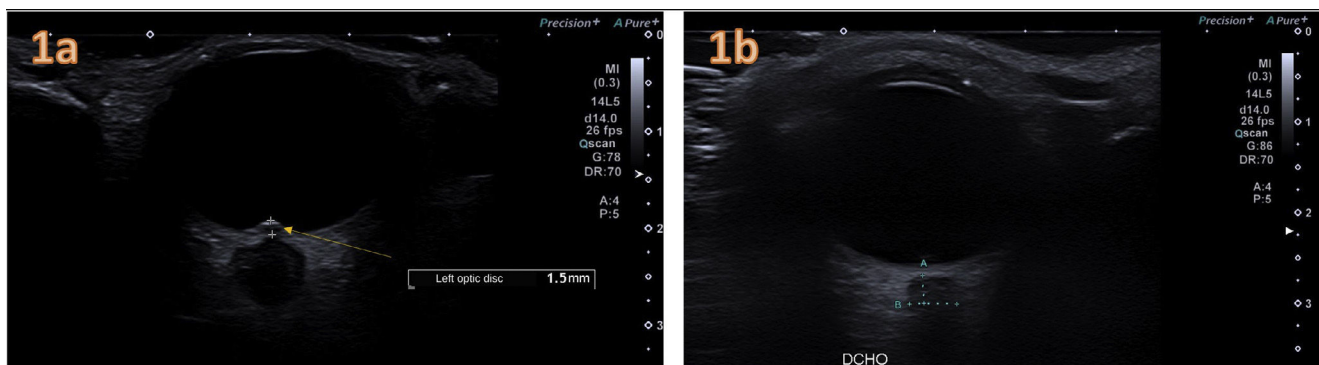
(a) Ocular ultrasound of the left optic disc on day 1 of the stay. The 1.5 mm elevation/protrusion of the optic disc exceeded the proposed 0.6 mm threshold for the suspicion of IICP and even the stricter threshold of 1 mm for confirmed IICP and the revised range for papilloedema (0.6–1.2 mm).² (b) Follow-up ultrasound scan at 5 days after initiation of treatment and clinical improvement, without visualization of optic disc protrusion.
